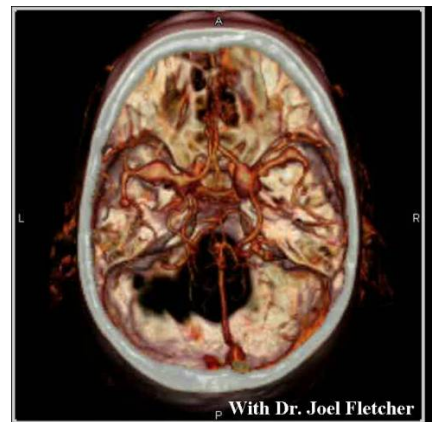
4D imaging of brain aneurysm with dynamic CT.
